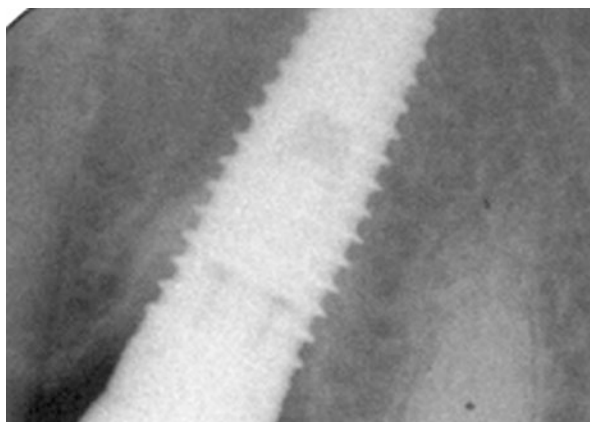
In the radiograph taken 1 year after regenerative treatment, there is apparent bone fill to the first thread of the implant in the preoperative areas of bone loss. It is possible that re-osseointegration has occurred based on the absence of a black line next to the implant. Other regeneration procedures will frequently show some bone fill, but there will be a prominent black line (space) next to the implant, possibly indicating that re-osseointegration has not occurred
